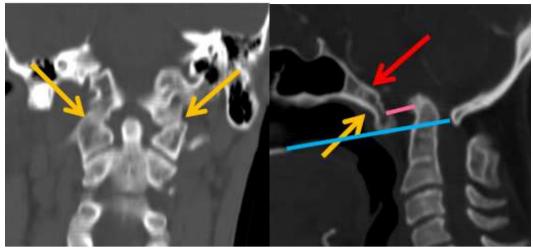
Atlanto-occipital assimilation. A. CT coronal section showing complete atlanto-occipital assimilation on right side and incomplete atlanto-occipital assimilation on left side. B. CT sagittal section showing complete atlanto-occipital assimilation, short Clivus, violation of Chamberlain's line-basilar invagination and atlantoaxial dislocation.
